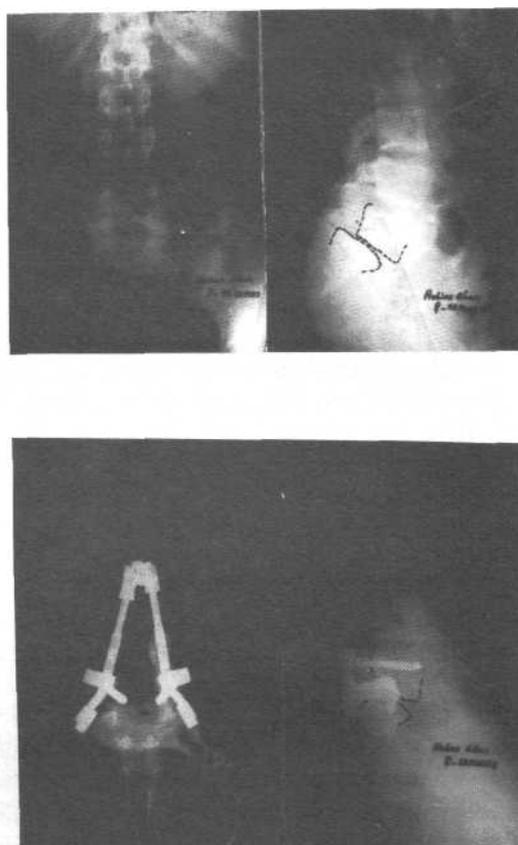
Pre-operative A/P and lateral x-rays.
